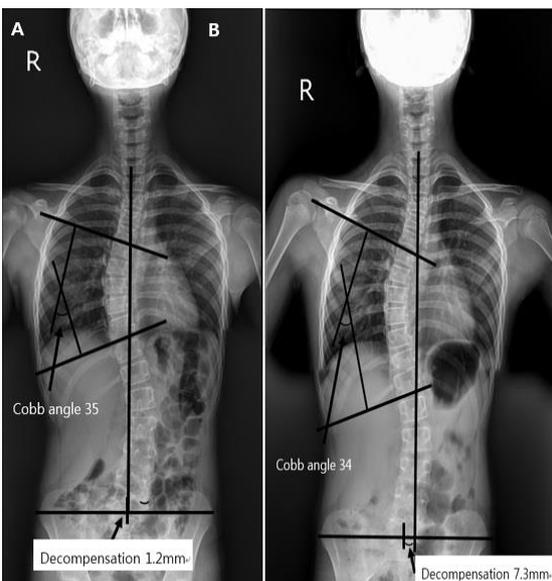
X-ray of patient 2. (A) Before brace (B) After 6 months Boston brace treatment
